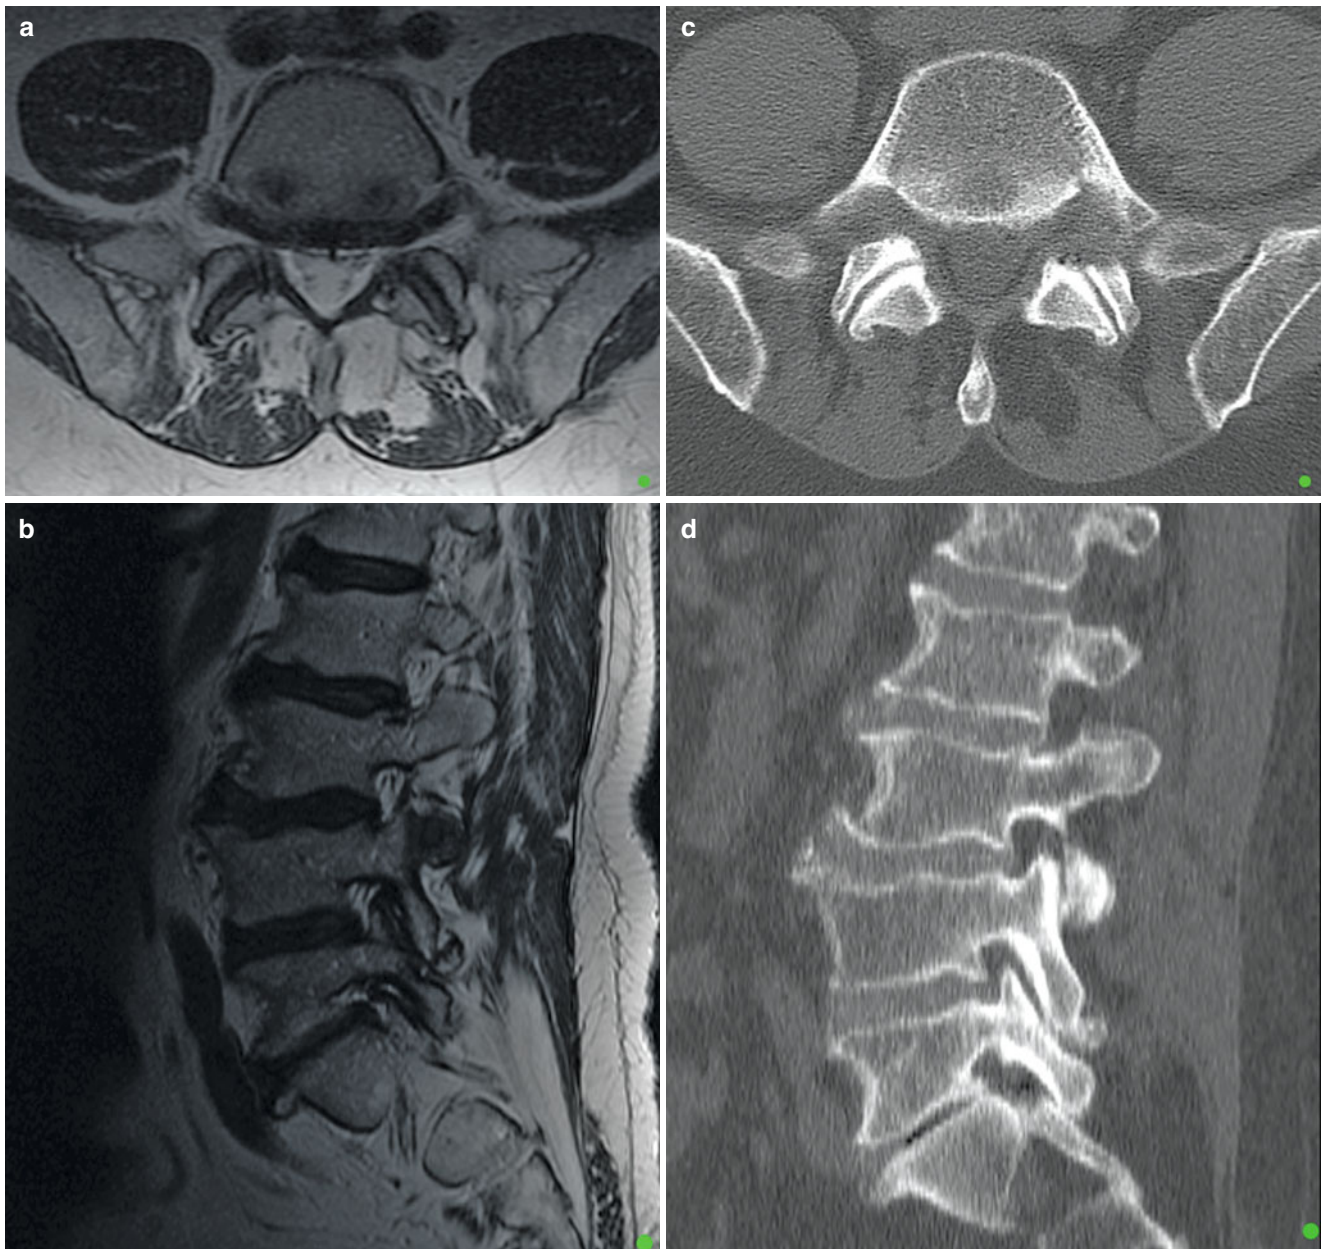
(a, b) Preoperative MRI showing symptomatic left foraminal stenosis. (c, d) Postoperative CT scan showing the area of foraminal decompression after removal of the undersurface of the superior articular facet (foraminoplasty)
